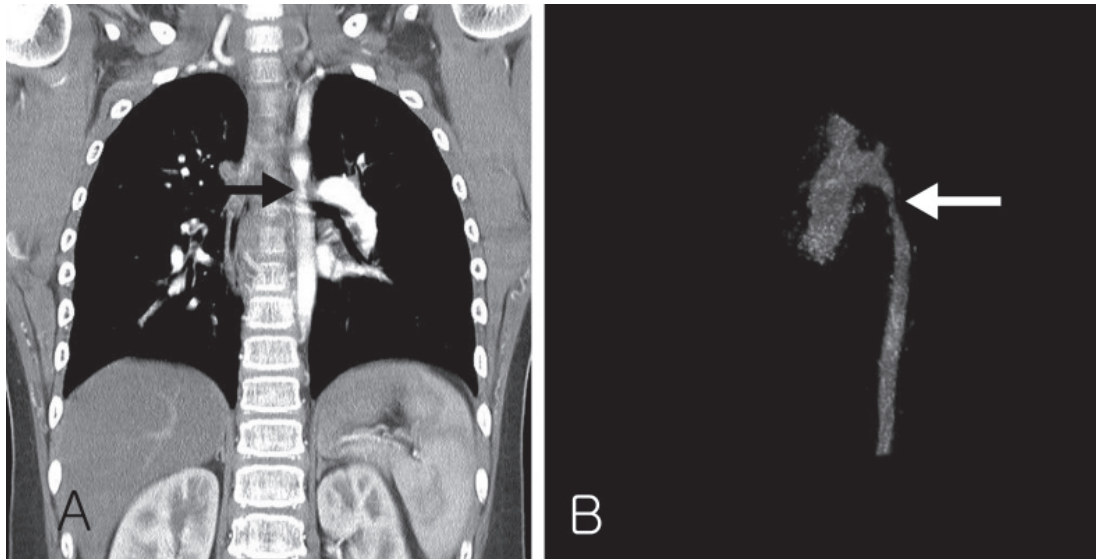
Chest computed tomography(A) and three-dimensional reconstruction(B) images show coarctation of the aorta (arrows).
